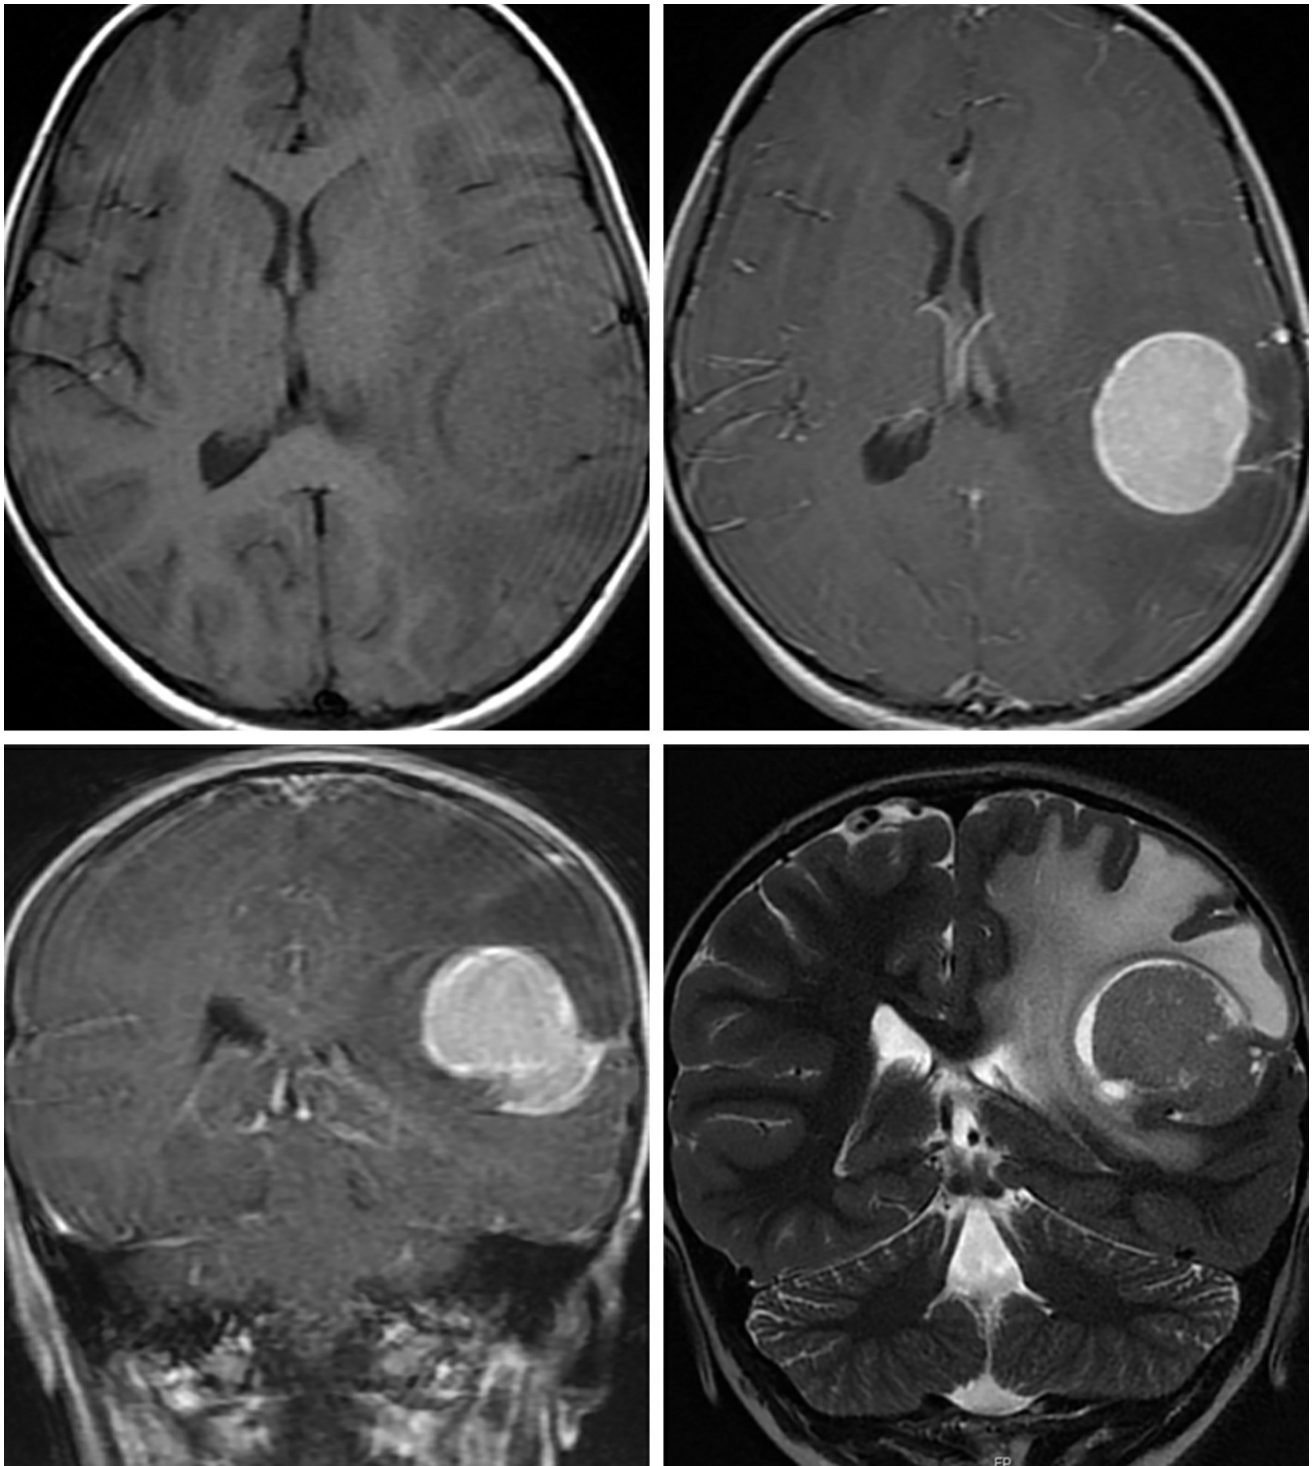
T1-weighted precontrast (top left) and postcontrast (top right [axial] and bottom left [coronal]) images show a brightly enhancing superficial lesion in the left parietal lobe. Although sometimes present, no dural tail is visible in this example of PXA. A cyst or CSF cleft around the mass is clearly visible on coronal T2-weighted imaging (bottom right). The large amount of surrounding hyperintense edema is also more clearly
